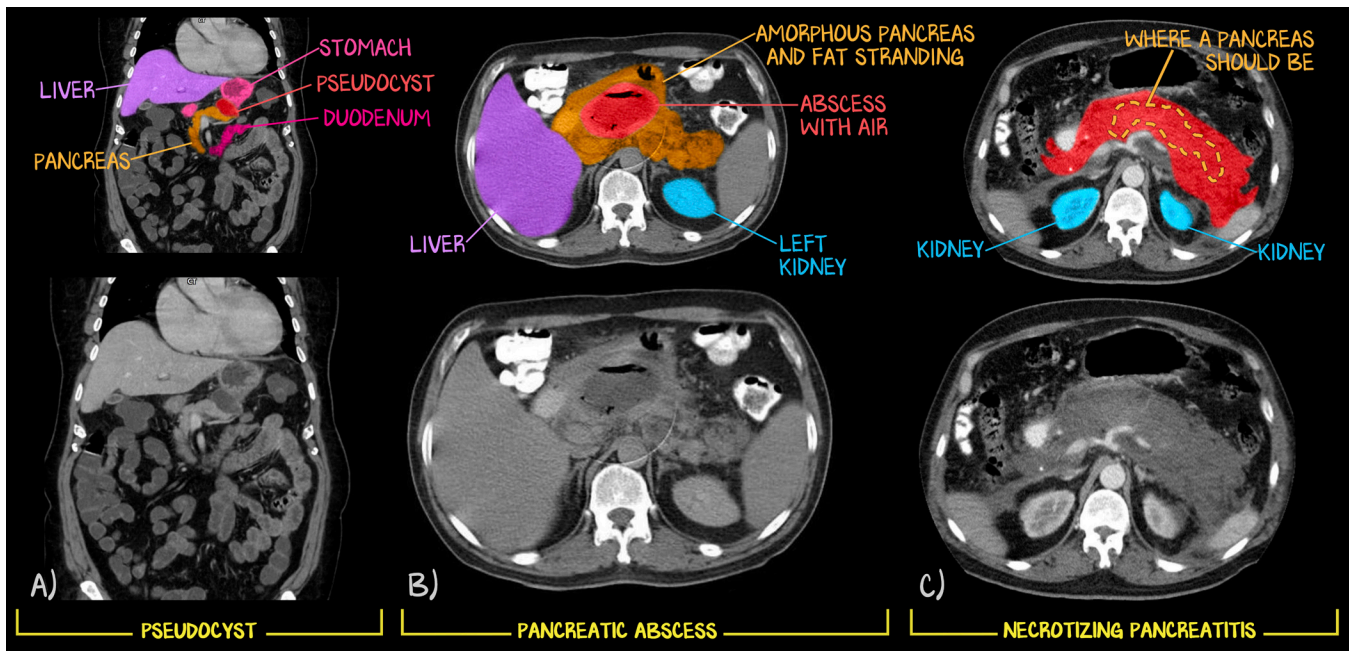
Radiographical Acute Pancreatitis Complications
